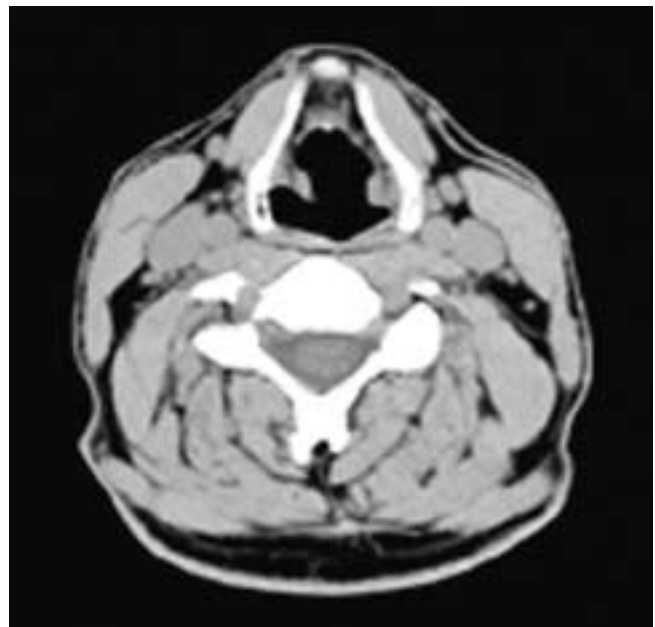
Axial CT scan shows a small, dense mass in the superior thyroid notch region of the larynx. This was ectopic thyroid tissue.
